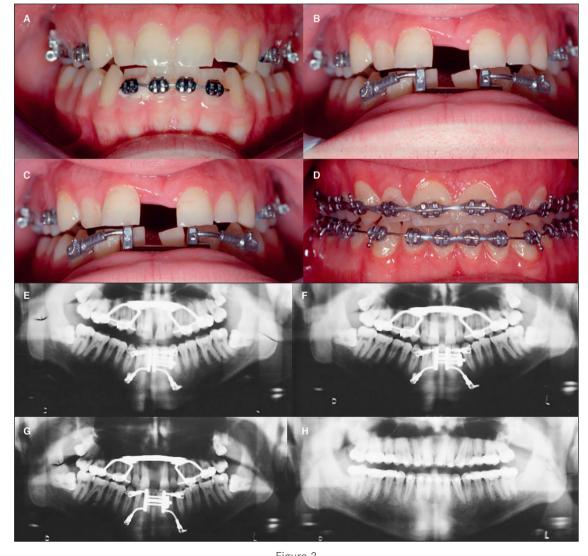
25-year-old man underwent SARPE/MSDO for OSA. (A-D) Clinical progression. (E-H) Radiographic progression.
